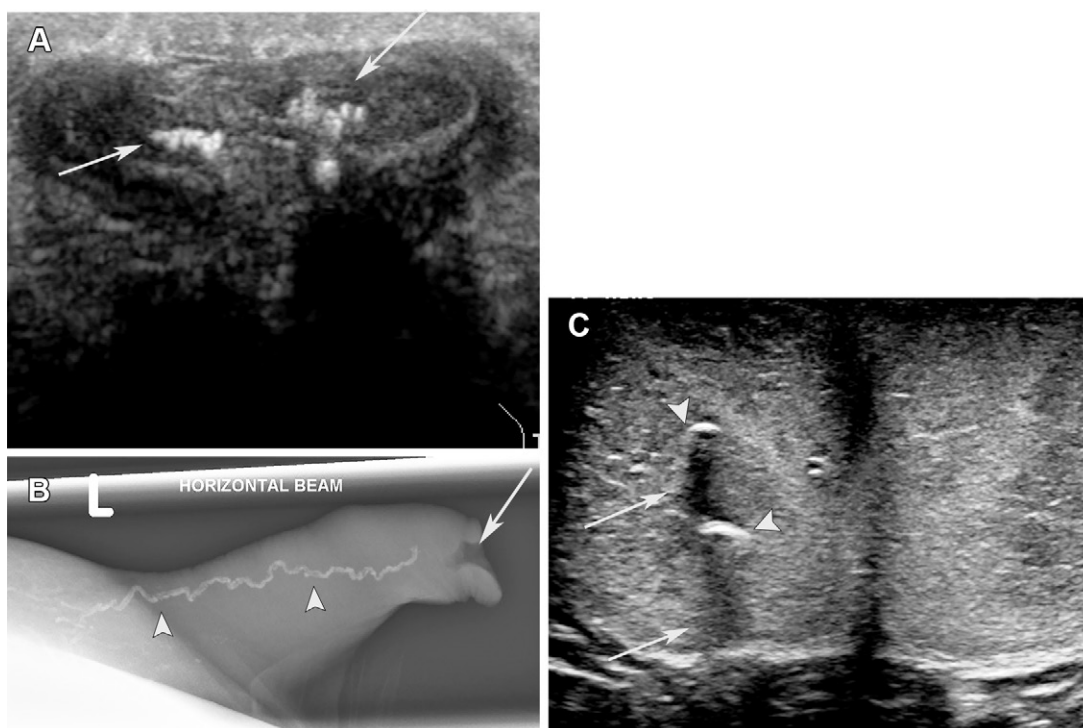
Considerations in differential diagnosis of calcified plaques of PD. (A) Transverse US image in a 63-year-old man shows extensive calcifications in the corpora cavernosa on both sides (arrows). The central location and contiguous alignment along and involving the cavernosal artery are indicative of vascular calcifications. (B) Radiograph acquired with a mammographic unit in the same patient as in A shows vascular calcification (arrowheads). Note the small ischemic ulcer at the glans (arrow). (C) Transverse US image shows that gas locules (arrowheads) in the cavernosa from intracavernosal injection can mimic calcified plaque, but the location, reverberation artifacts, and dirty posterior shadowing (arrows) can help to differentiate between them.
